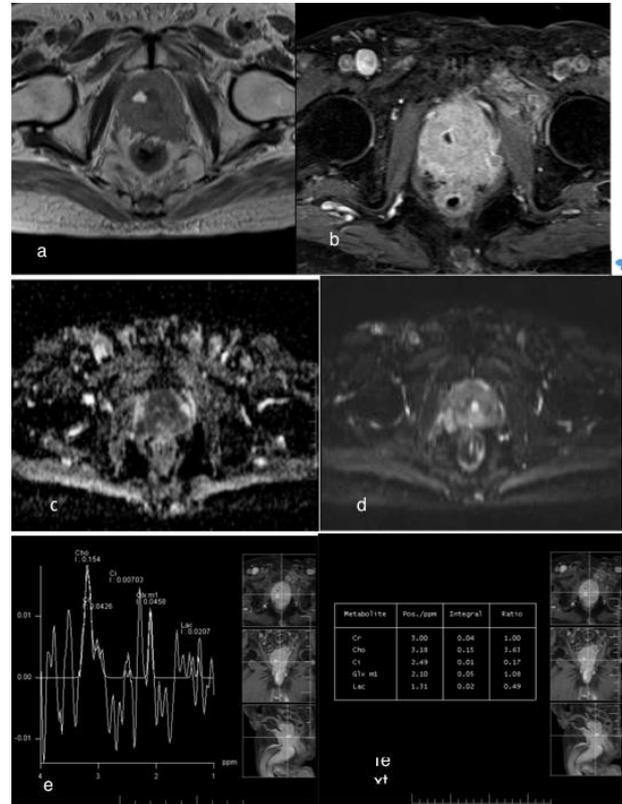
MRI of carcinoma prostate in 76 years old patient. (a): Axial T2WI showing heterogenous signal intensity lesion in the prostate; (b): Axial T1 Fat sat Post contrast MRI showing intense heterogenous enhancement in the prostate mass; (c): Axial DWI showing restriction; (d): The lesion is showing low ADC (e) & (f): Showing increased Choline and reduced citrate level.
